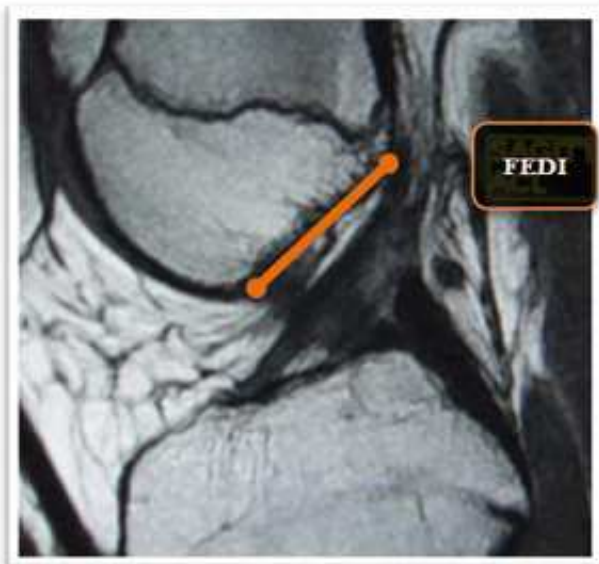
FEDI vector in sagittal MRI view.
